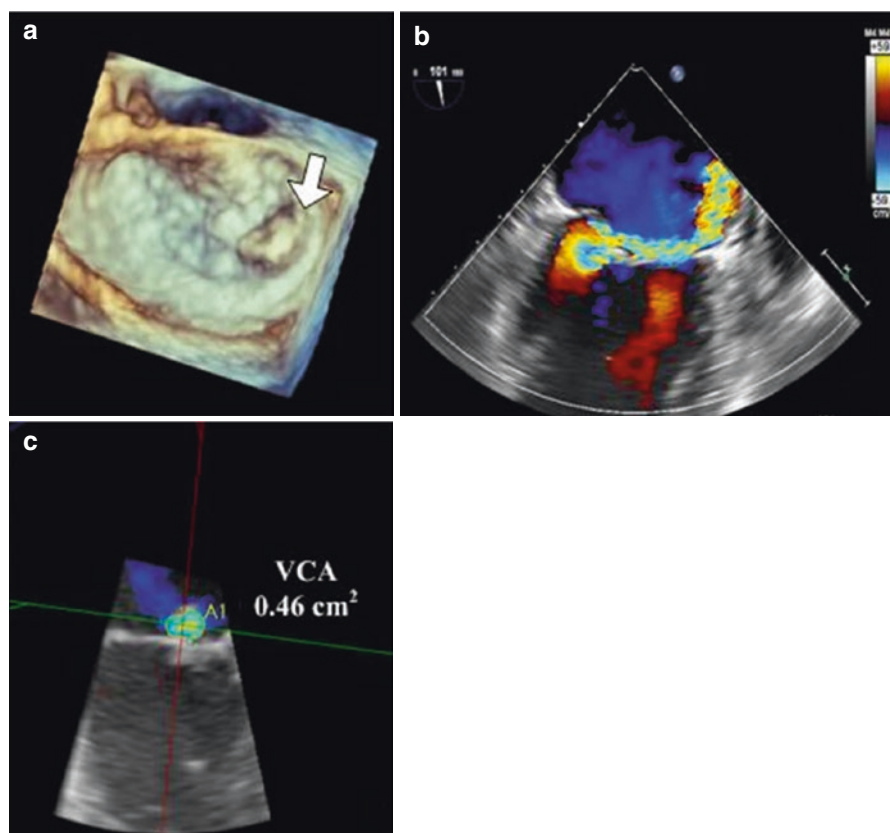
Echocardiographic evaluation of mitral regurgitation. Transesophageal 3D echocardiography with en face view of the mitral valve reveals isolated flail of P3 segment of the posterior leaflet (panel a). A highly eccentric jet of mitral regurgitation is seen by color Doppler (panel b). 3D-guided 2D planimetry demonstrates rounded vena contracta with area of 0.46 cm^2 consistent with severe mitral regurgitation
